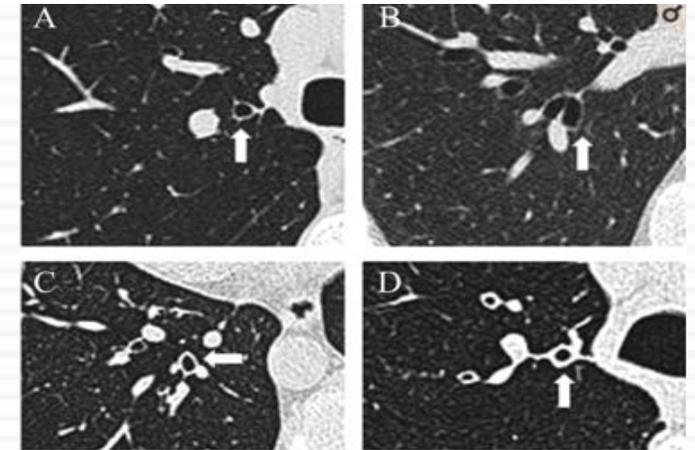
Representative images of patient categories based on the presence or absence of BWT and BE on HRCT scans as follows: (A) BWT+/BE+; (B) BWT-/BE+; (C) BWT+/BE+; and (D) BWT+/BE-.
